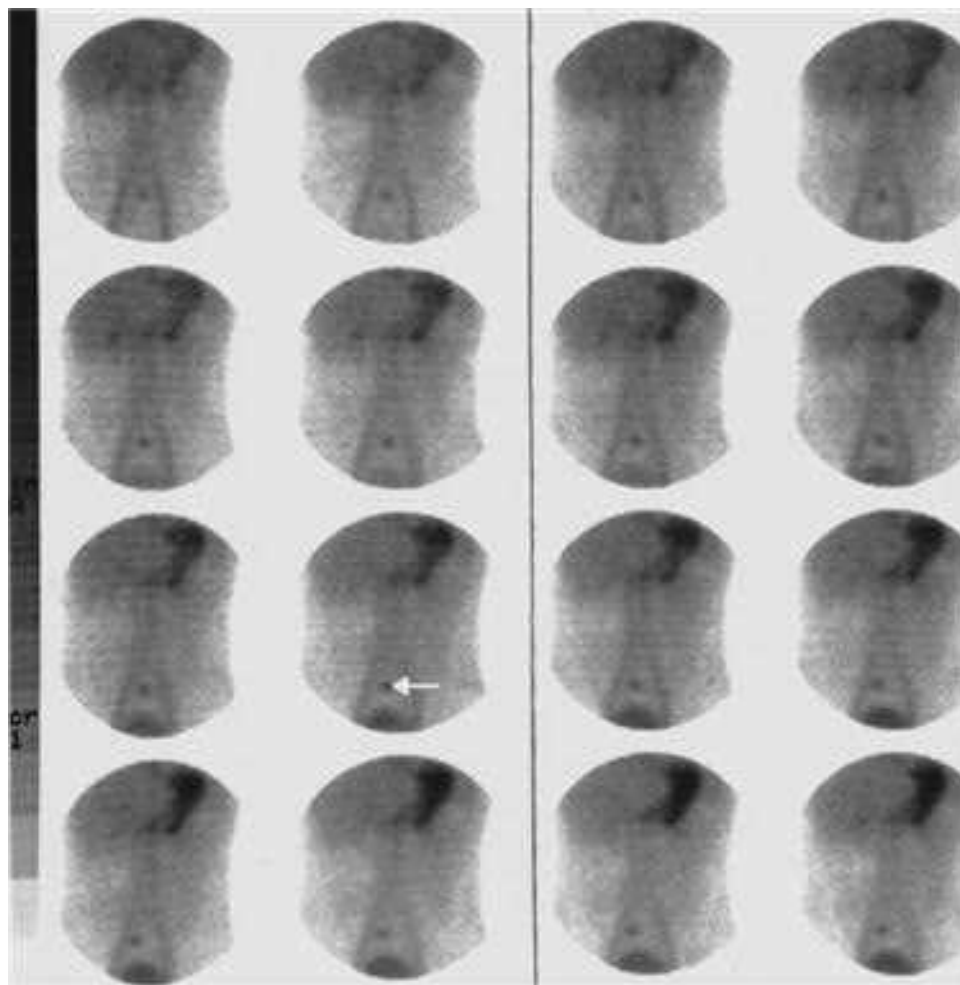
Meckel's diverticulum with ectopic gastric tissue. The diagnosis was made in this patient using ^{99m}Tc -pertechnetate scintigraphy. The study revealed an abnormal focus of radiotracer accumulation in the right lower quadrant (*arrow*).
